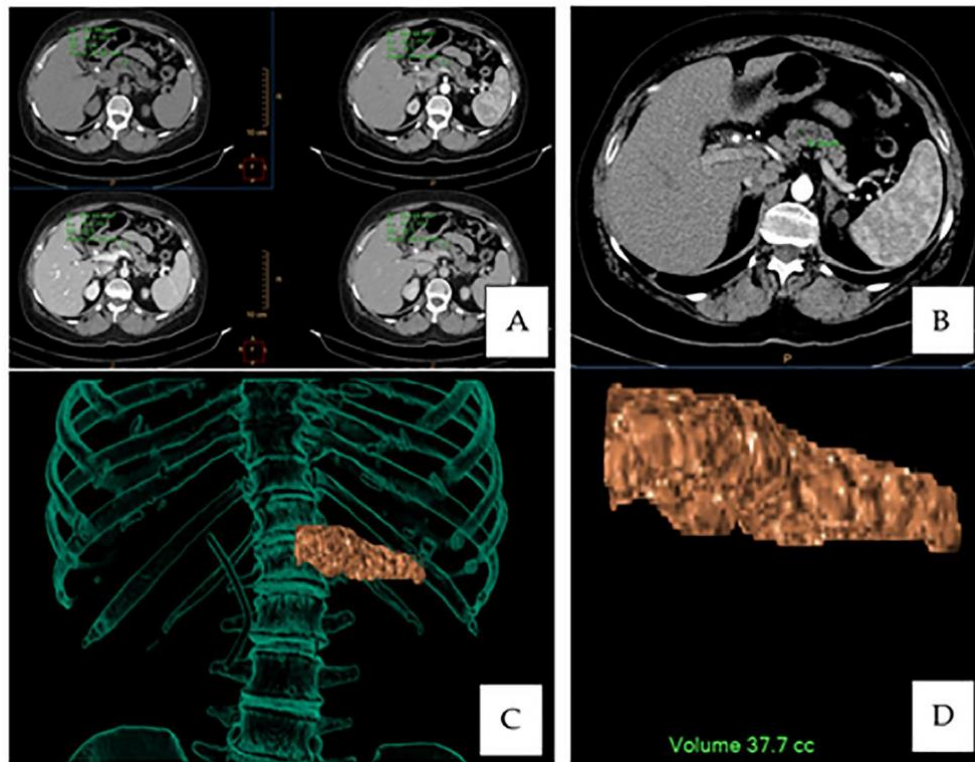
Parameter acquisitions: (A) Pancreatic density on a multisequence CT scan at the site of resection. (B) Main pancreatic duct measurement. (C,D) Volumetric rendering overlay and estimated pancreatic remnant volume
